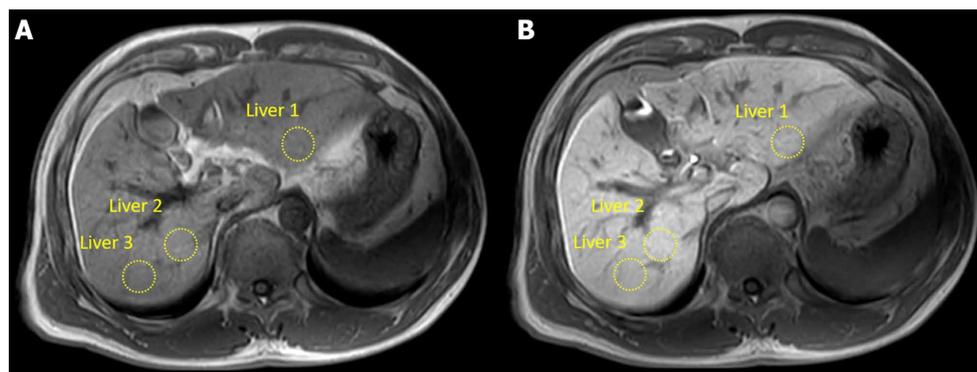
Precontrast (A) and postcontrast (B) T1-weighted images in a 72-year-old male with a METAVIR score of F4. The hand-drawn regions of interest of the liver are shown (dotted closed curves). RE was 0.45. RE: Reduction rate of T1 relaxation time.
